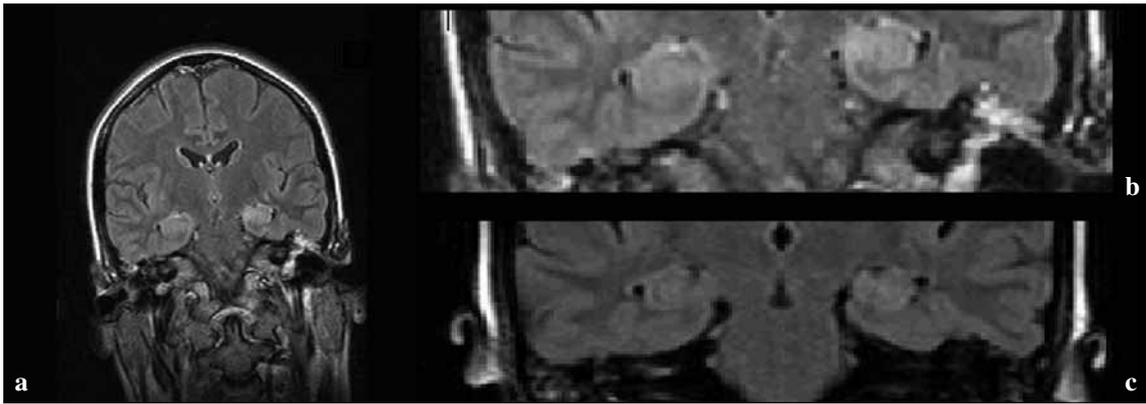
MRI with coronal FLAIR sequences shows high signal intensities in the hippocampus and gyrus parahippocampus bilaterally, consistent with the diagnosis of limbic encephalitis (a, b). Seven days later, following intravenous immunoglobulin treatment, these lesions are unchanged (MRI not shown). However, one week after repeated plasma exchange and seven weeks after debut of status epilepticus, regress of the temporal lesions is seen. Slight hippocampal atrophy is visible (c).
